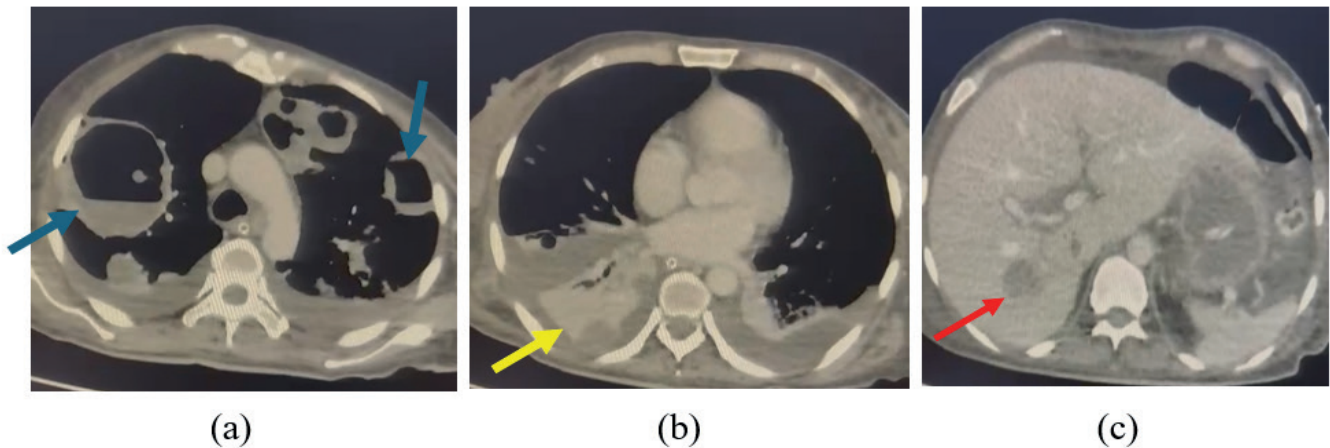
Chest CT scan with contrast showing abscess cavities in both lung fields (blue arrows) associated with probable septic pulmonary embolism (a), atelectasis of the right lower posterior lateral segment (yellow arrow) caused by fluid filling of the segmental bronchi (b). Contrast-enhanced abdominal CT scan showing a liver lesion in segment VI/VII (red arrow) of indeterminate appearance (c).
